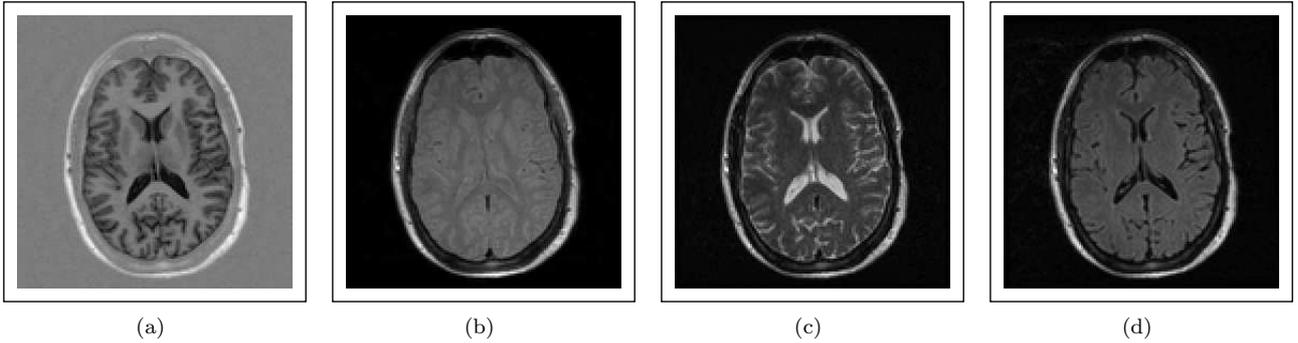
New data collected with SENSE coil in quadrature. (a) Inversion Recovery Turbo Spin Echo (IRTSE), (b) Variable Echo - Proton Density (VE-PD), (c) Variable Echo - T2 (VE-T2), and (d) Fluid-Attenuated Inversion Recovery (FLAIR)
